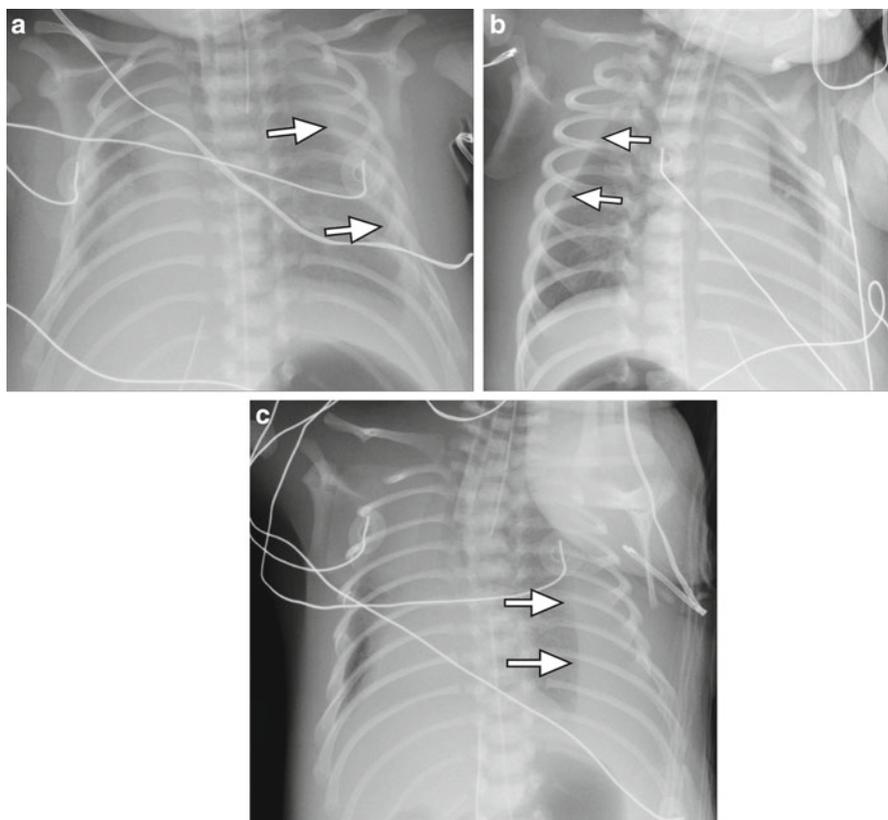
Neonate with pulmonary lymphangiectasis with chylous effusions. (a) Supine radiograph of the chest shows diffuse and bilateral lung haziness with a moderate left pleural effusion (arrows). Right side down (b) and left side down (c) lateral decubitus views better delineate the presence of effusions. Note that the nasogastric tube tip is in the mid esophagus. The patient has been intubated in the interval between the supine to the lateral decubitus views
